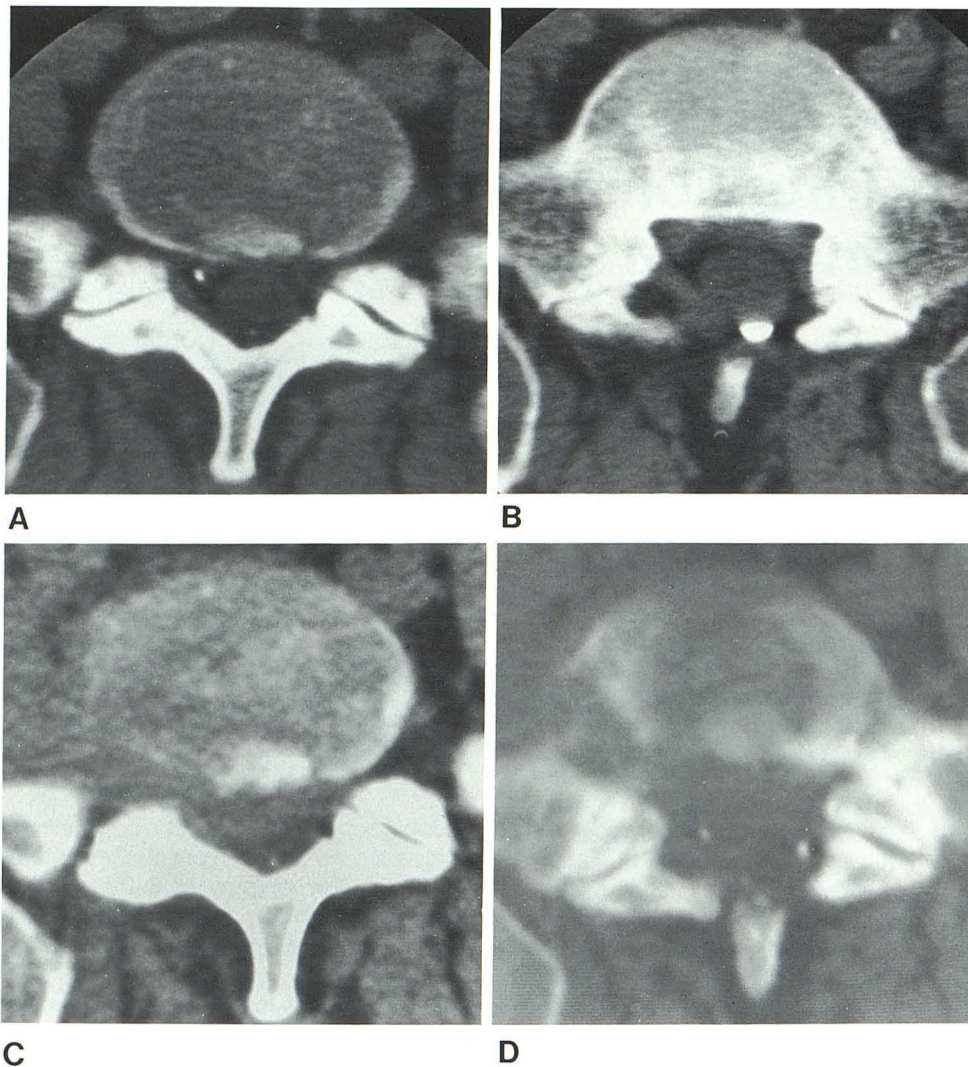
Case 1. CT scans before (A and B) and 4 months after (C and D) chemonucleolysis with chymopapain. A, Normal L5–S1 disk; minimal bulging, but no herniation is seen. Changes on the myelogram prompted surgery. B, Normal-appearing S1 vertebral end-plate with previous laminectomy and residual Panthopaque and scarring. C, After chymopapain treatment, L5–S1 disk margins on right side fade into a paraspinal soft-tissue mass. Paraspinal and intraspinal fat planes are obliterated. D, Bone destruction on right side of S1 vertebral body; lesion has irregular edge, not seen on pretreatment scan (cf. B).
